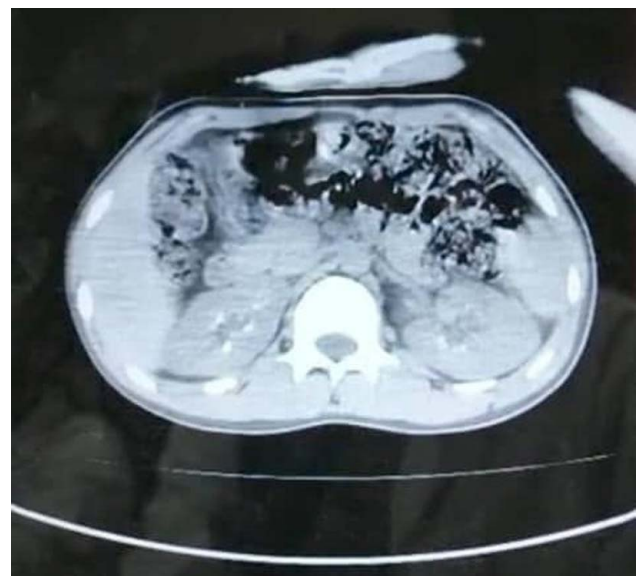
A computed tomography scan showed pulpal calcifications.
